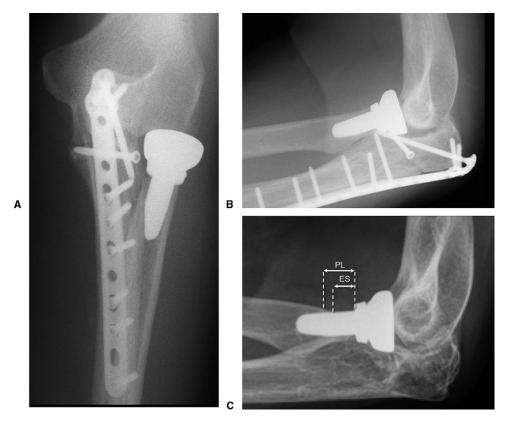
A Anteroposterior x-ray in neutral rotation optimizing dorsal and volar cortex visualization showing no stress shielding. B Lateral view optimizing medial and lateral cortex visualization showing no stress shielding. C Stress shielding was quantitated by measuring periosteal (PL) bone loss and exposed stem (ES). Copyright © 2012 Mayo Foundation. Used with permission.
